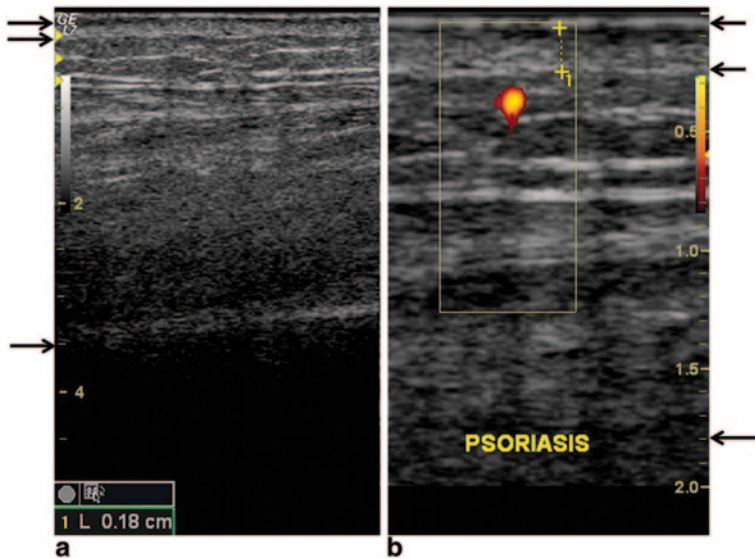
High-frequency ultrasound of a psoriatic plaque (b) compared with healthy skin (a). The epidermis and dermis appear thicker (*black arrows*). There are hypoechoic bands in the upper dermis, and there is an increased blood-flow signal within the dermis demonstrating it is an active psoriatic plaque
